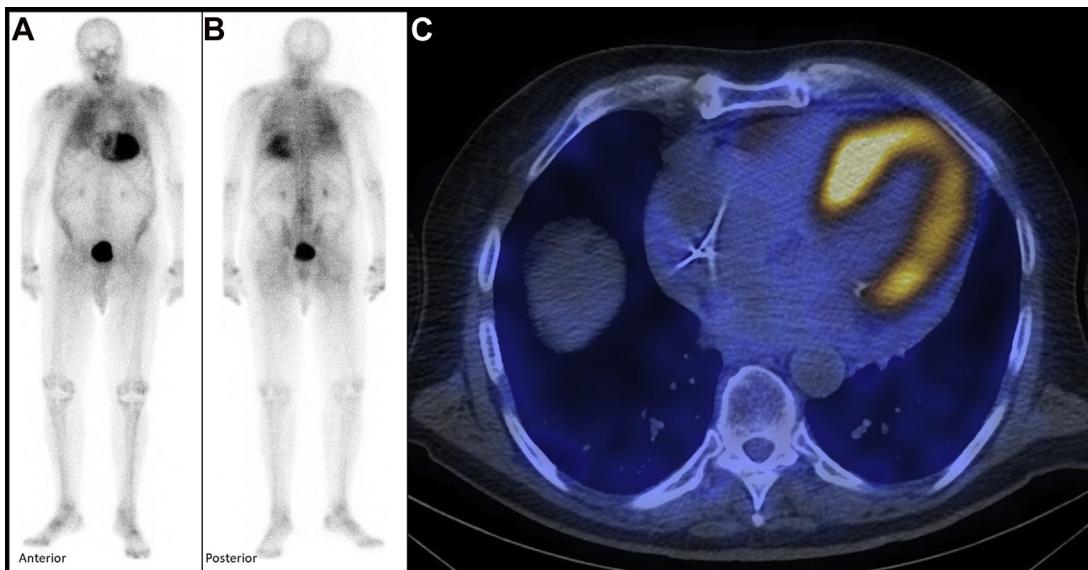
99mTc-DPD scintigraphy: 83-year-old man with wtATTR-CM showing Perugini grade 2 cardiac uptake on whole-body anterior (A) and posterior (B) scintigraphy and left ventricular myocardial uptake (C) on single-photon emission computed tomography. DPD, 3,3-diphosphono-1,2-propanedicarboxylic acid.
